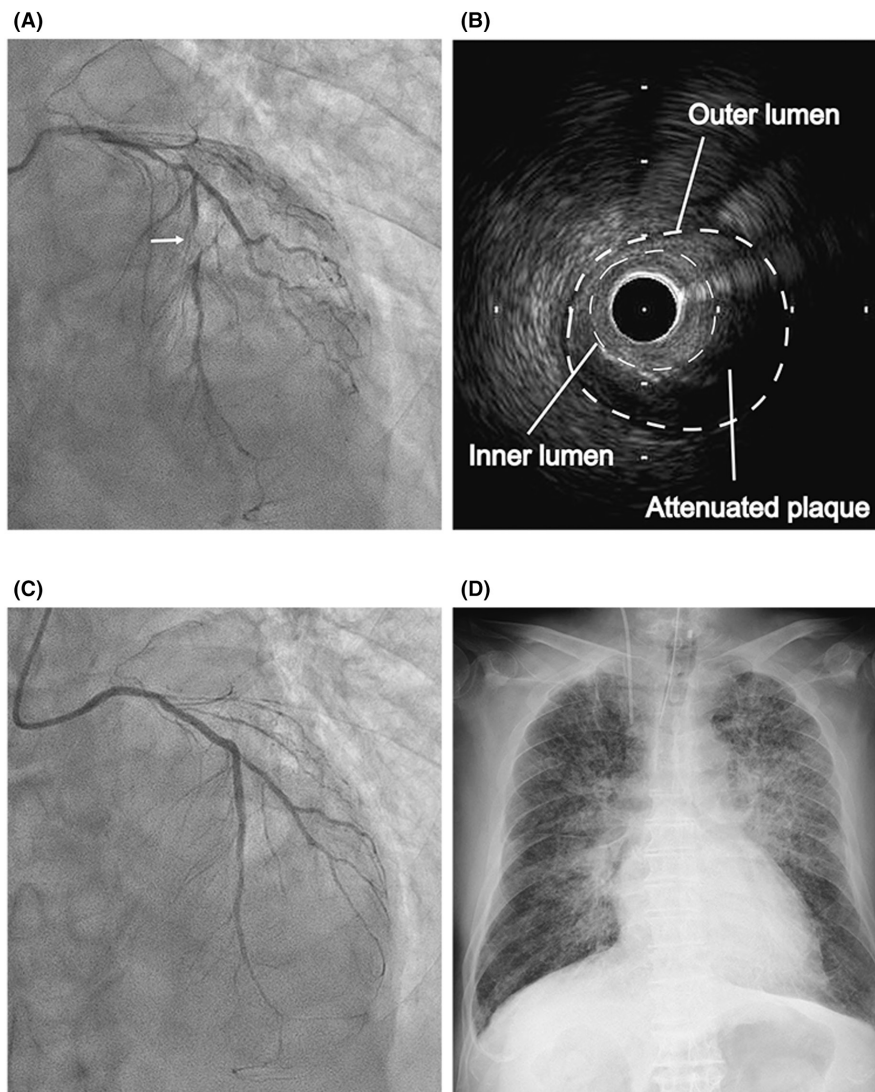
Coronary angiogram and intravascular ultrasound of the stenosis lesion and a chest X-ray after stent implantation. (A) Emergency coronary artery angiography revealed 99% stenosis in the middle left anterior descending coronary artery (LAD). (B) Intravascular ultrasound after plain old balloon angioplasty revealed severe stenosis with vulnerable attenuated plaques at the LAD lesion. (C) LAD angiography revealed no stenosis after stent implantation. (D) A chest X-ray revealed severe lung congestion after percutaneous coronary intervention.
